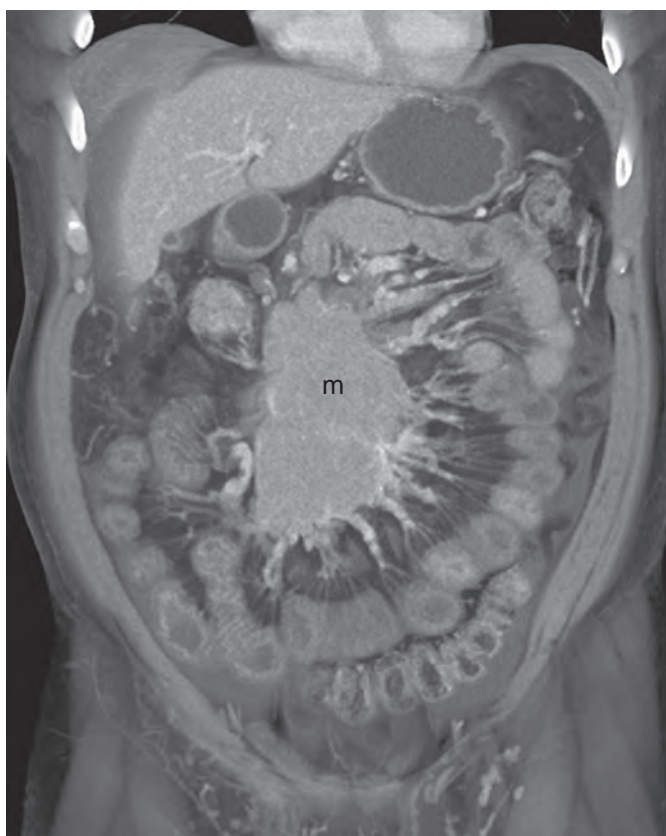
Carcinoid tumor causing mesenteric ischemia. Coronal volume-rendered contrast-enhanced CT image demonstrates a large mesenteric carcinoid tumor (m) encasing the mesenteric vessels, resulting in diffuse small bowel wall thickening related to ischemia.
